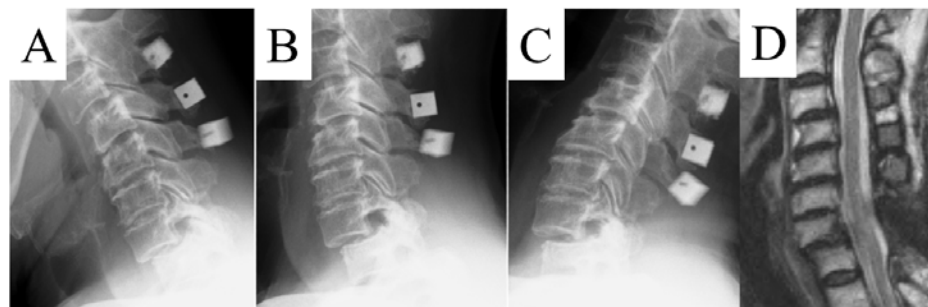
Plain radiography one year after laminectomy (the second surgery) from C6 to T1 in flexion (A), neutral (B) and extension (C) positions. MRI T2-weighted sagittal image one year after laminectomy (the second surgery) (D).
